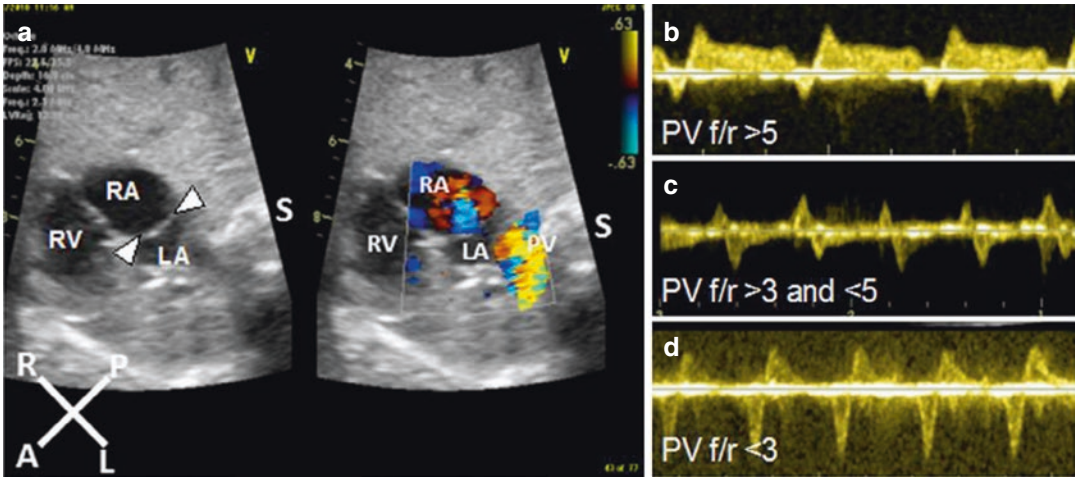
Four-chamber view in a fetus with HLHS demonstrating restrictive atrial septum by 2D imaging. (a) Pulse wave Doppler interrogation of pulmonary vein (PV) flow in a fetus with HLHS. PV flow with f/r ratio > 5 . (b)
